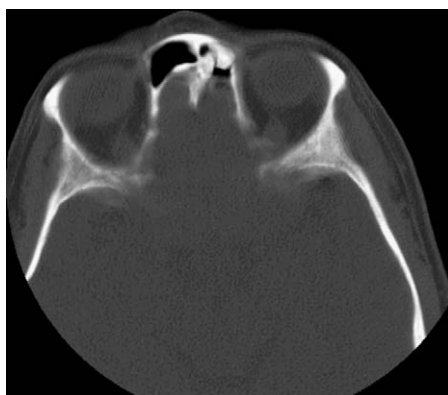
Axial sinus CT image of a left frontal recess osteoma.
